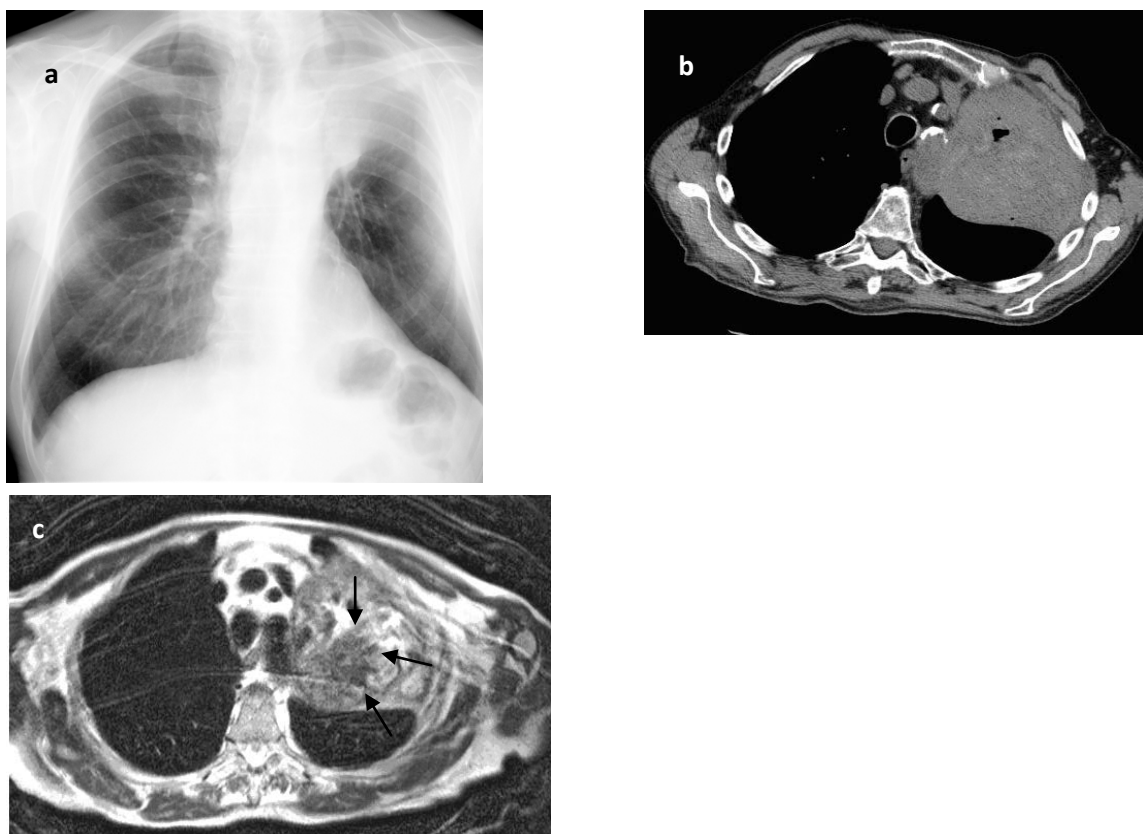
a) chest radiograph. Frontal view. Homogeneous shadow in the upper right lung field with oblique bottom border. Dome of the diaphragm on the left is raised (located above the right); b) computed tomography of the thorax at the level of IV thoracic vertebra. There is a zone of increased density corresponding segments basale apicoposterior, anterior with small area of destruction; c) magnetic resonance imaging of the chest at the level of thoracic vertebra IV: axial scan. T2 WI. Hypo-intense zone is defined on the background of the hyper-intense of the magnetic signal corresponding to the image of the primary tumor (arrows) on the background of obstructive atelectasis due to filling of the bronchi with secretions. Hilar bronchogenic carcinoma causing obstruction of the left upper lobe bronchus with atelectasis.
